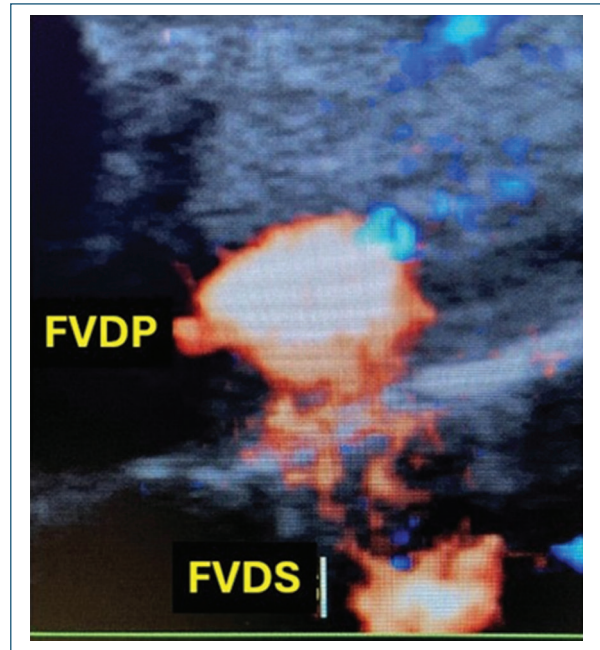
Deep dorsal venous leakage and superficial dorsal venous leakage in Doppler ultrasound HD (courtesy of the authors).
